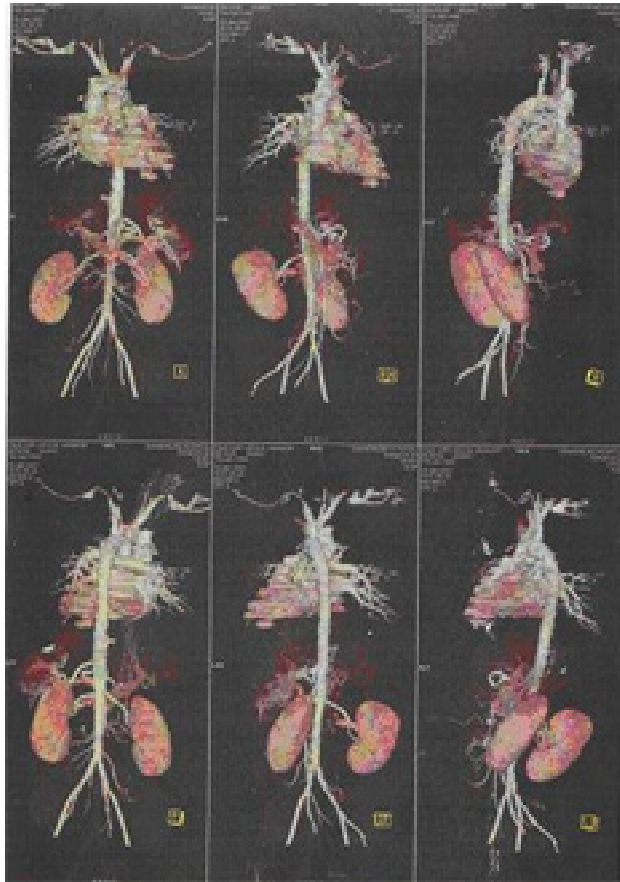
CT angio image of the patient at the time of discharge.
